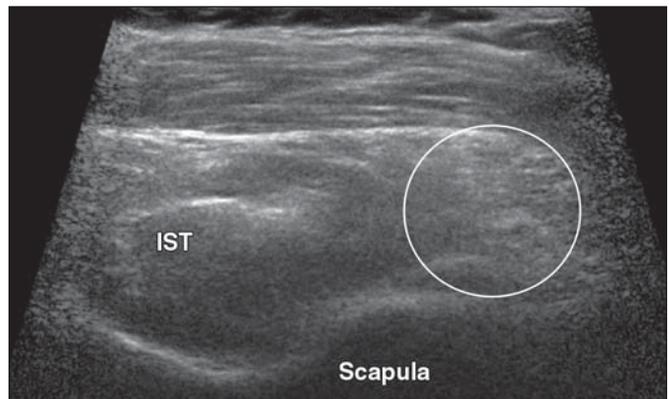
49-year-old man with asymptomatic teres minor muscle atrophy. Short-axis ultrasound image of teres minor and infraspinatus (IST) musculature shows loss of volume and increase in echogenicity of teres minor (*circle*) in keeping with teres minor atrophy.
